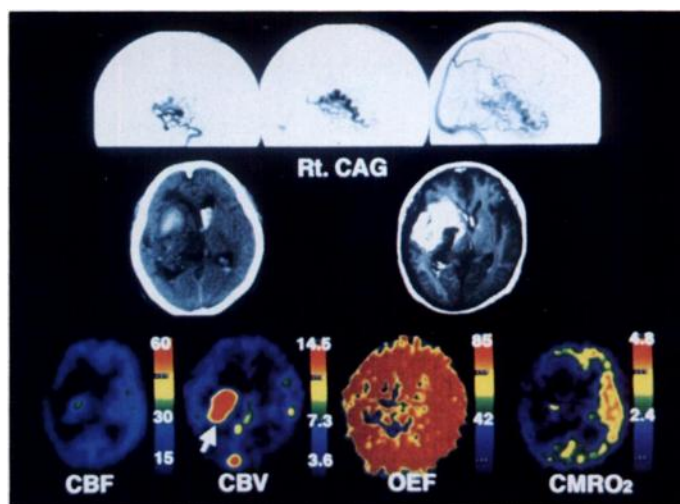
Initial PET study (obtained on Day 31 of hospitalization), CAG (top row), CT, MRI (middle row), CBF, CBV, OEF and CMRO₂ images (bottom row) taken at a level parallel to and 4.5 cm above the orbito-meatal line. A large proportion of the hematoma has been absorbed. Note generalized misery perfusion, hypometabolism and increased CBV in the AVM. Arrow indicates the AVM on the CBV image. Results of arterial gas analysis were: pH 7.513, PaCO₂ 28.1 mmHg, PaO₂ 94.2 mmHg, SaO₂ 97.9% and hemoglobin concentration 10.5 g/dl during inhalation of 3 liter/min of O₂ mixed air. Values described below are for normal volunteers aged 22–65 yr, mean age 45 yr. CBF values were 44 ± 7 ml/100 g/min in the cortex and 25 ± 4 ml/100 g/min in the white matter; CBV values were 4.5 ± 1.0 ml/100 g and 2.8 ± 0.7 ml/100 g, respectively. Mean CBF-to-CBV ratio was 9.8 ± 1.3 min⁻¹, and the OEF value was 44.3% ± 5.1%. The CMRO₂ values were 3.5 ± 0.5 ml/100 g/min in the cortex and 2.0 ± 0.3 ml/100 g/min in the white matter.
